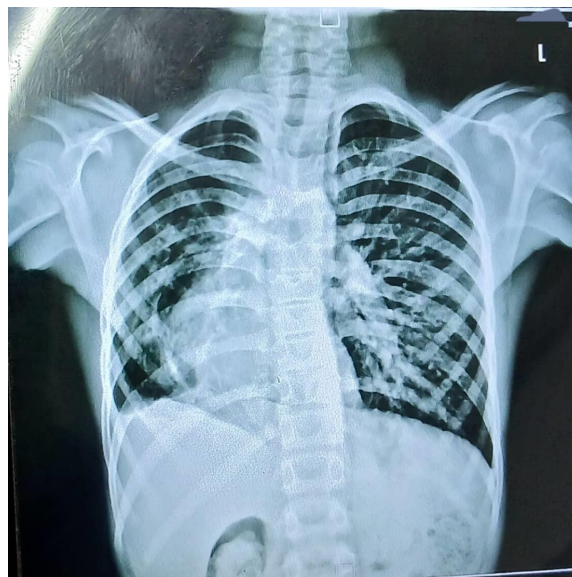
Chest X-ray on the posterior-anterior view showed dextrocardia with bilateral infiltrates (brochiectatic changes).
